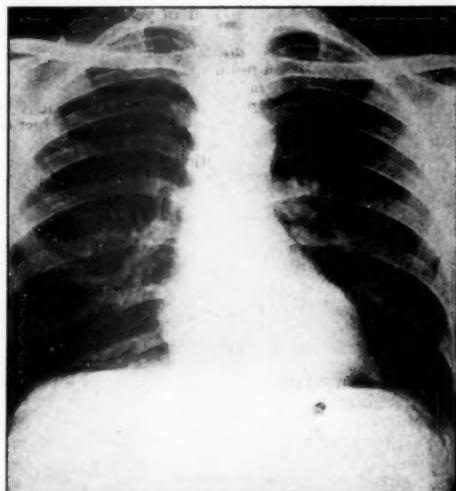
Chest radiograph of coal-miner (twenty years) and sand-blaster (two and a half years), showing generalized nodular shadows—coal-miners' pneumoconiosis and/or silicosis.
